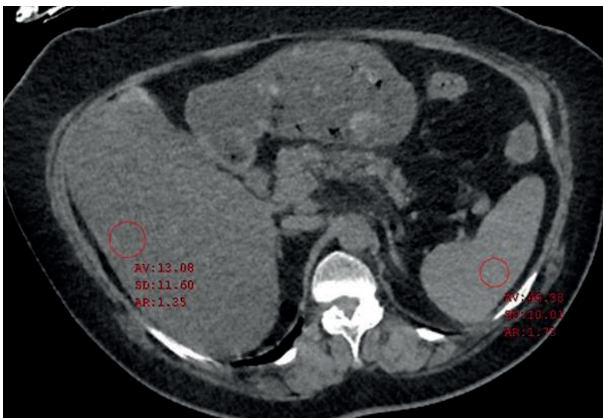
Density measurements of liver and spleen in non-contrast abdominal CT examination.
